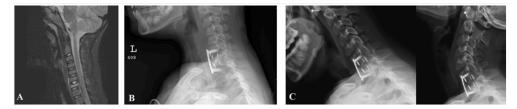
7 y/o female presenting with neck pain extending into the right hand, right sided weakness and decreased sensation, and right sided torticollis. (A) Sagittal MRI demonstrating vertebra plana at C7 with soft tissue invasion and cord compression and (B) sagittal radiograph after C7-T1 fusion. (C) Sagittal radiograph of flexion (left) and extension (right) 7.5 years after fusion.
